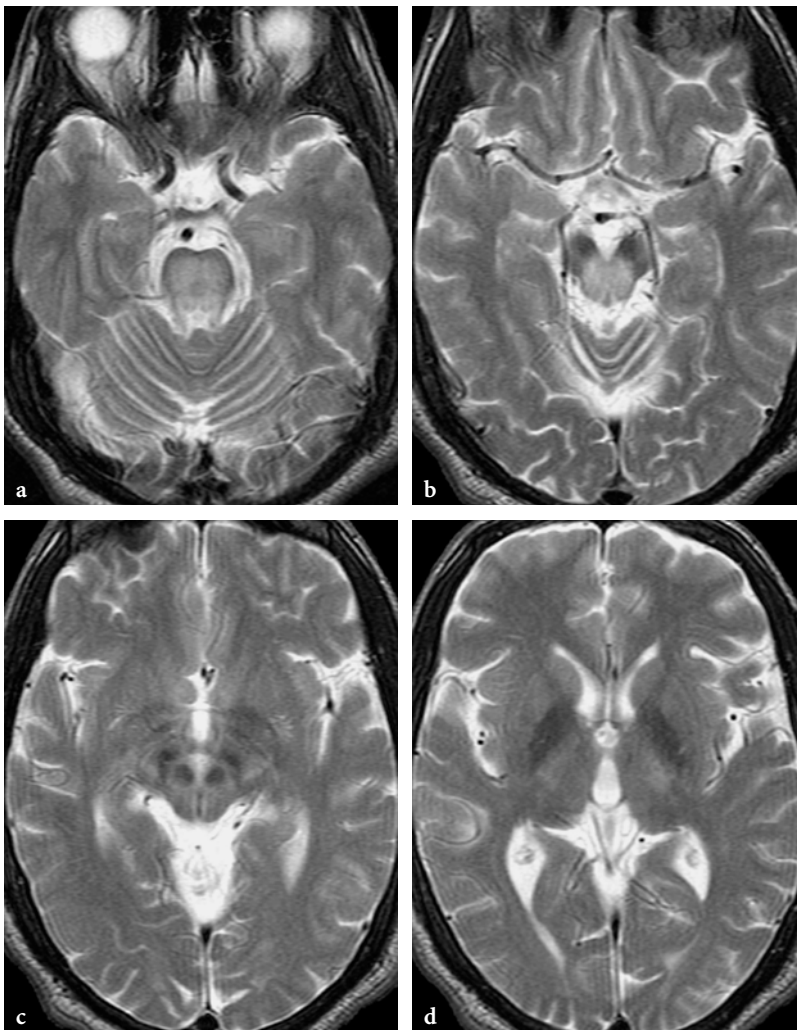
a–d. MR imaging findings in a patient with Wilson disease presenting mainly with cerebellar manifestations. a–d Axial T2-weighted fast spin-echo images. Hypointensities are seen within the globi pallidi, red nuclei, and pars reticulata of the substantia nigra, but otherwise deep gray matter structures appear to be normal. Faint hypersignal is noted within the posterior limbs of internal capsules. The pars compacta of substantia nigra, the tegmental upper brainstem structures and more caudally, almost the entire cross-sectional area of brainstem (including pons, not shown here) exhibit abnormal hypersignal. Prominent cerebellar atrophy
